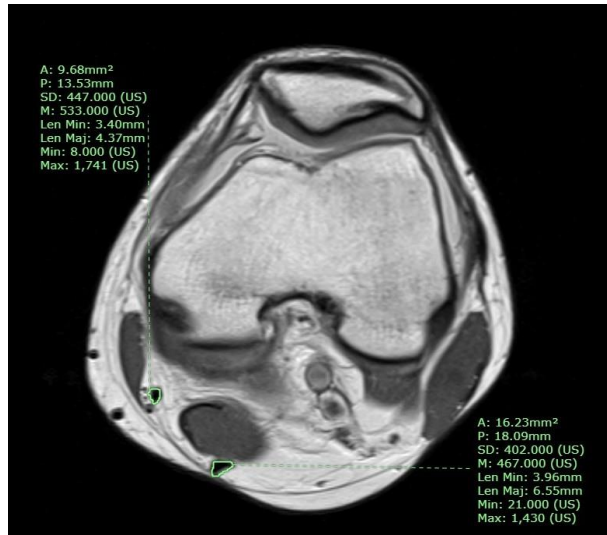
Axial-plane magnetic resonance imaging showing measurement of the cross-sectional area of the two hamstring tendons. After identifying the semitendinosus and gracilis tendons, magnification was increased by 2× in all cases to improve measurement accuracy. Manual tracing was used for the measurements.
